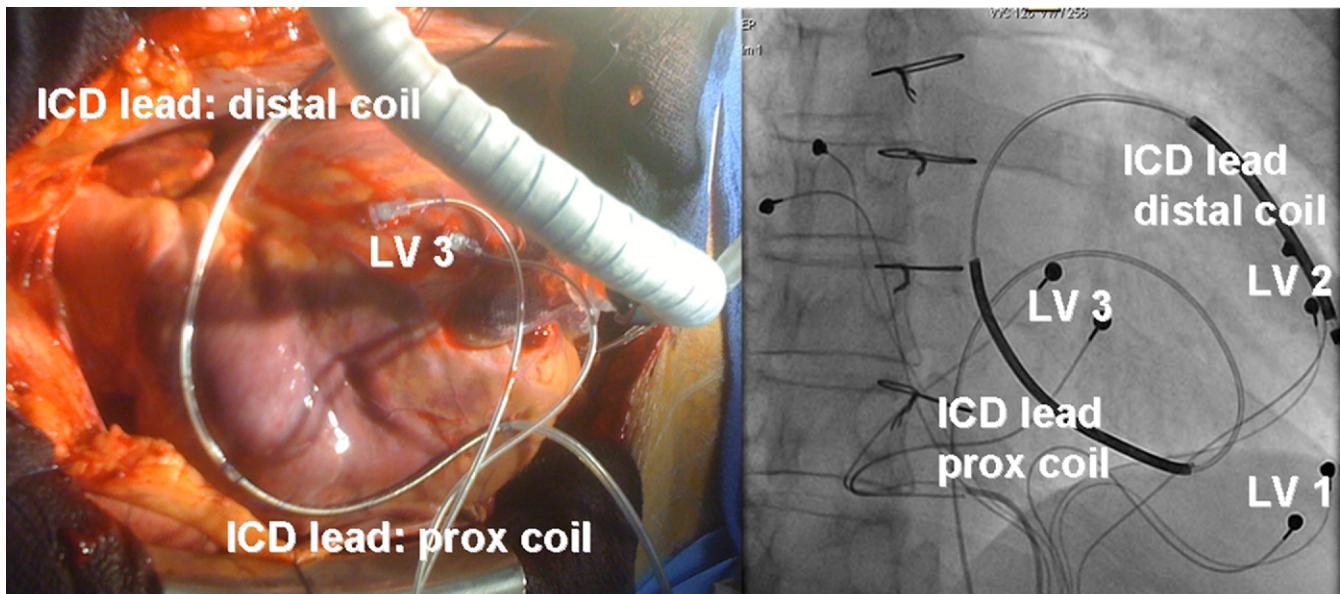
A: Distal coil was secured to the lateral LV wall. B: The X-ray positions of the ICD and 3 LV pacing leads. ICD = implantable cardioverter defibrillator; LV = left ventricle.
